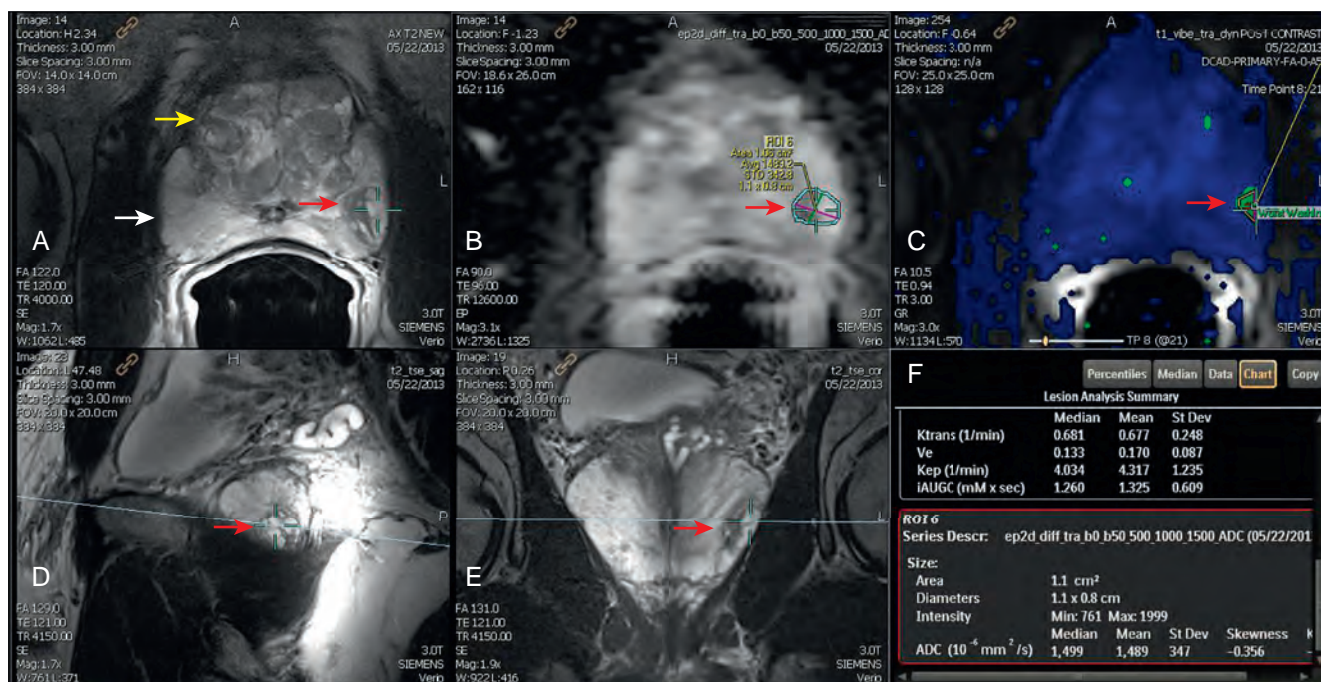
A 66-year-old man with a prostate-specific antigen of 7.0 and two prior negative biopsies. A 3-tesla multiparametric magnetic resonance imaging (MP-MRI) with an endorectal coil of the prostate was obtained. There were two suspicious areas. A, D, and E, Triplanar images in axial, sagittal, and coronal planes. The peripheral zone (white arrow) and the central gland (yellow arrow) are well visualized. The red arrow represents a well-circumscribed heterogeneous benign prostatic hypertrophy nodule (11 mm × 11 mm × 14 mm) within the peripheral zone with no communication to the central gland. The corresponding apparent diffusion coefficient map (B) demonstrates areas of heterogeneous restriction (761 × 10⁻⁶ mm²/sec). The lesion on the dynamic contrast enhanced MRI (DCE-MRI) (C) exhibits focal type 2 and 3 enhancement curves. The DCE-MRI quantitative analysis is listed (F). The patient underwent a fusion biopsy. The lesion was also appreciated on ultrasonography, and no cancer was detected.
